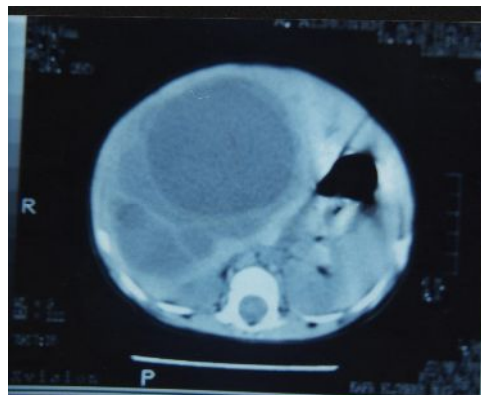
Abdominal CT of huge simple hepatic cyst
